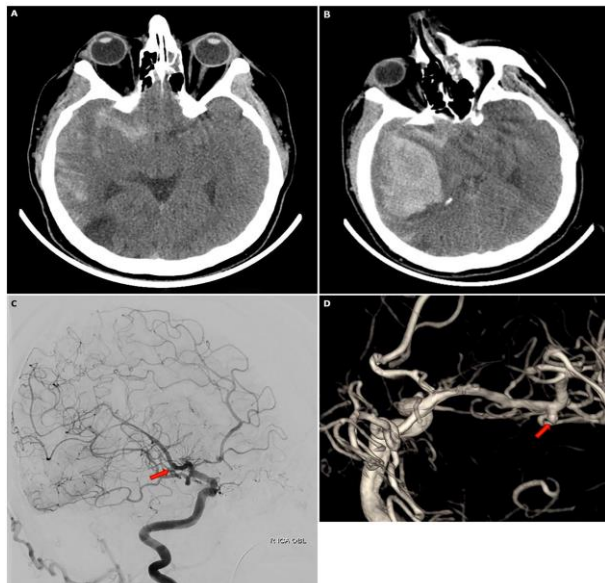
A. Preoperative cranial CT image showing SAH; B. Intracerebral hemorrhage is seen after re-bleeding; C-D. Preoperative DSA images showing right middle cerebral artery aneurysm.
